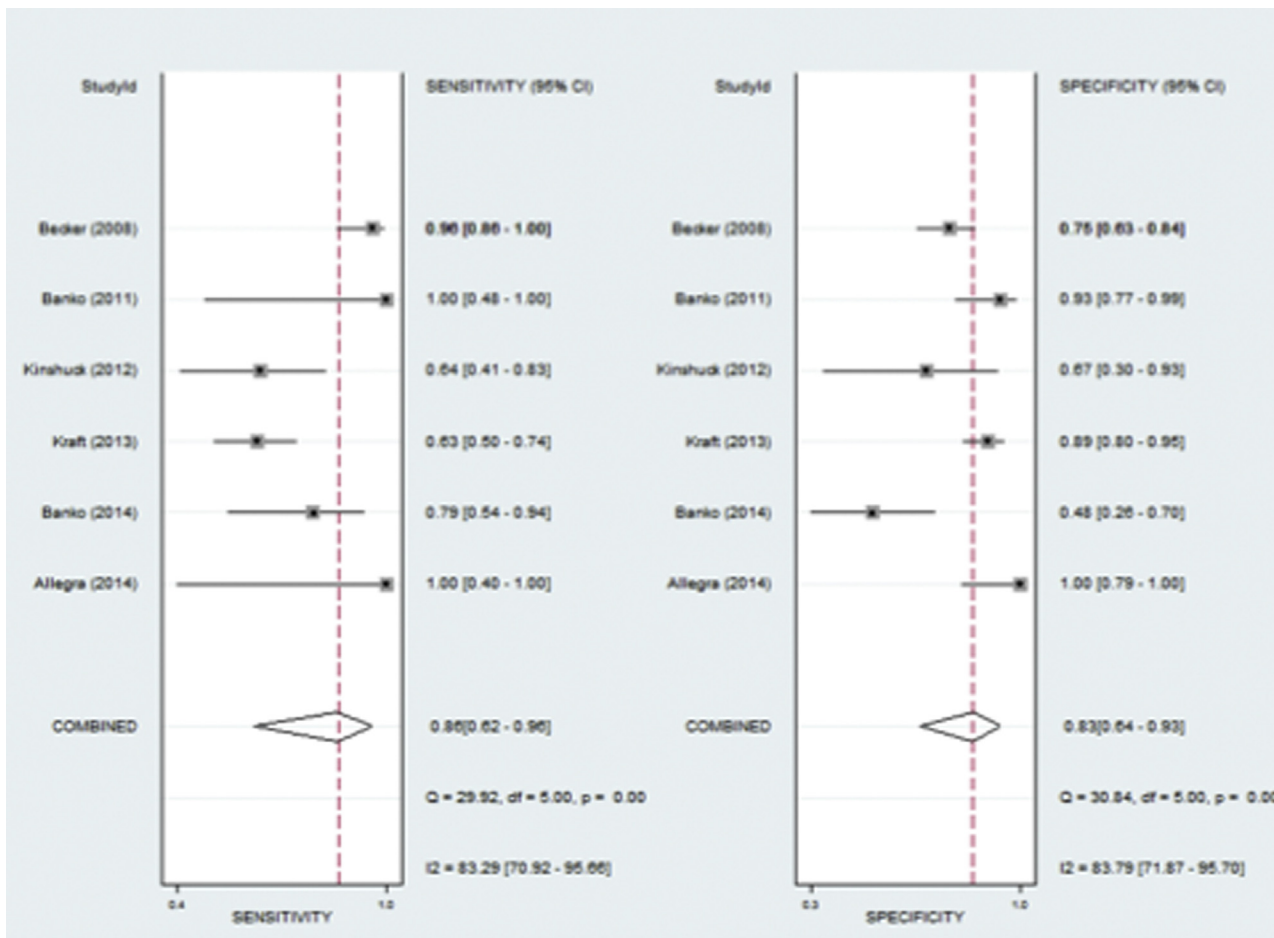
Meta-analysis of sensitivity and specificity of MRI.
